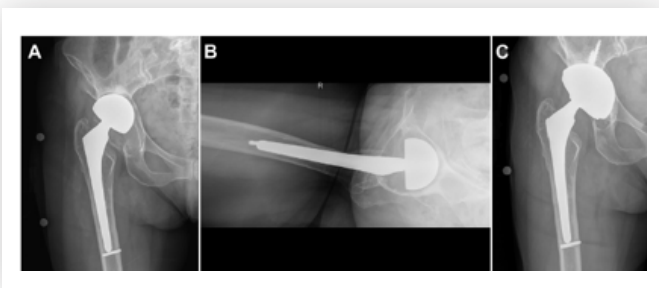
A 72-year-old female whom underwent a hip hemiarthroplasty at an outside facility for femoral head avascular necrosis 25 years before presenting at the author's with groin pain. She had significant acetabular bone loss (Paprosky Type IIB) with superior component migration as noted in the anteroposterior (A) and lateral (B) radiographs. She underwent a revision to a dual-mobility construct due to stability concerns. She remained stable at 5 years postoperatively (C).
